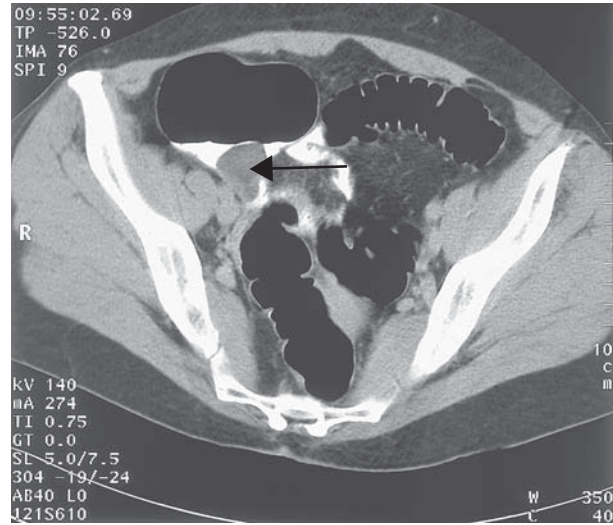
The CT with contrast clearly shows the lesion in the cecum.
